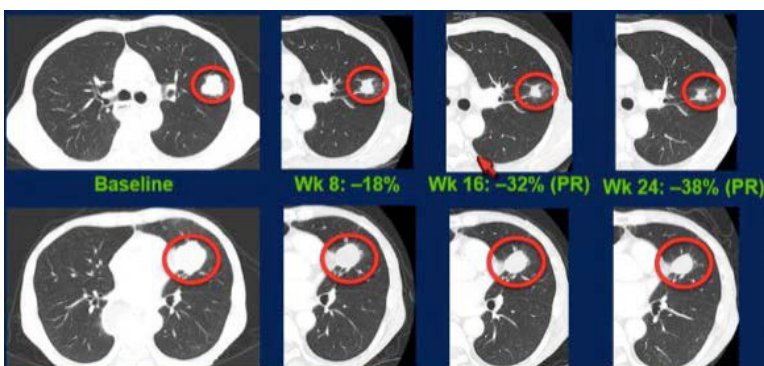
CT images of a patient with metastatic GEJ adenocarcinoma treated with pembrolizumab. Two lesions in the left lung are encircled in red, top and bottom panels. Patient achieved a RECIST partial response.
